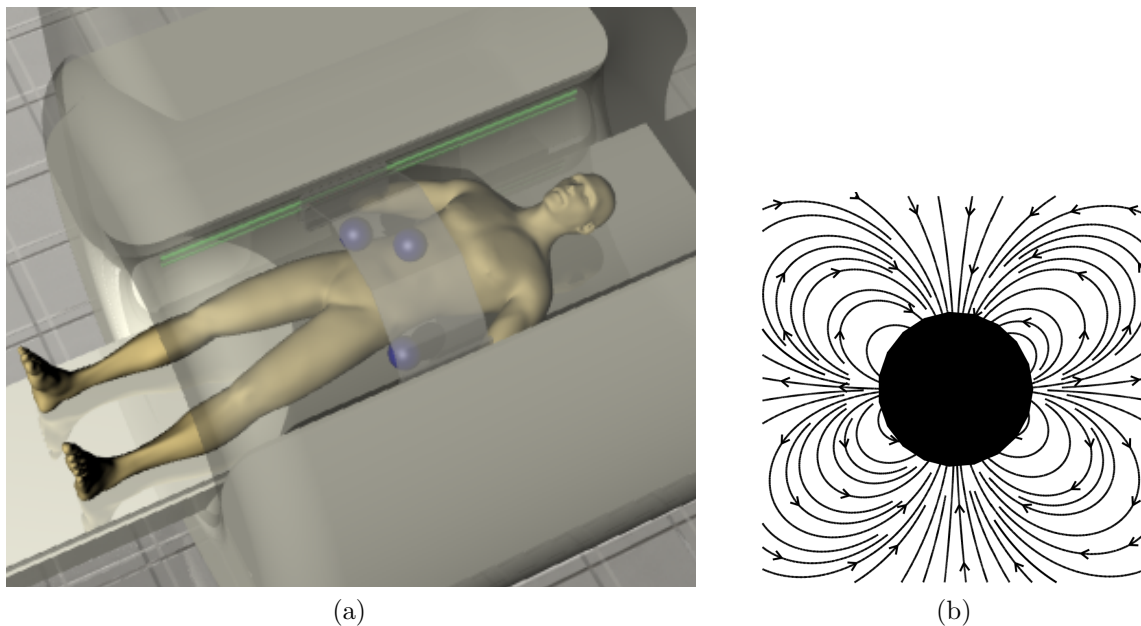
a) In Dipole Field Navigation, ferromagnetic cores are positioned around the patient inside an MRI scanner to distort the field, which generates strong directional forces for guiding therapeutic agents along a predefined vascular route; b) Magnetic gradient lines around a spherical core (dipole).
